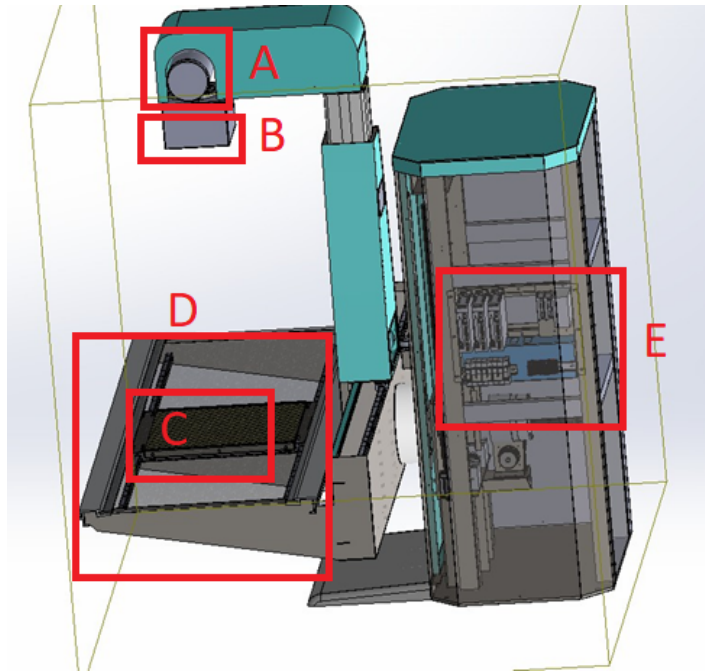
Main units connected to the system, also explained in the table 2.5. (A) X-Ray Tube, (B) Collimator, (C) X-Ray Detector, (D) Table, (E) Control and Driver.
